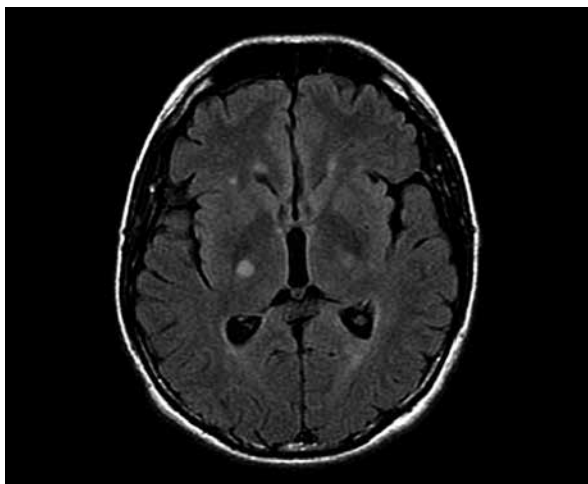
Case 3. Axial FLAIR MR image shows some bilateral, periventricular focal T2 hyperintensities localized also in the right thalamus and subinsular area.
